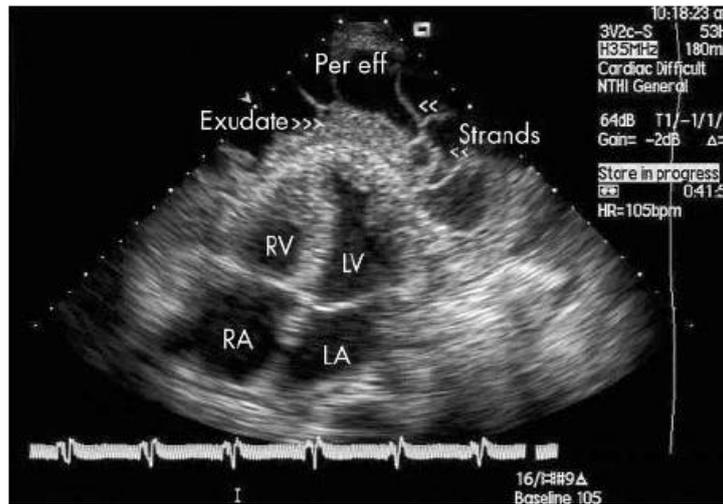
Apical four chamber view of a two dimensional echocardiogram of a patient with tuberculous pericardial effusion showing multiple fibrin strands as linear or band like structures crossing the pericardial space or protruding from the epicardium or parietal pericardium and exudates. LA, left atrium; LV, left ventricle; Per eff, pericardial effusion; RA, right atrium; RV, right ventricle [25]
